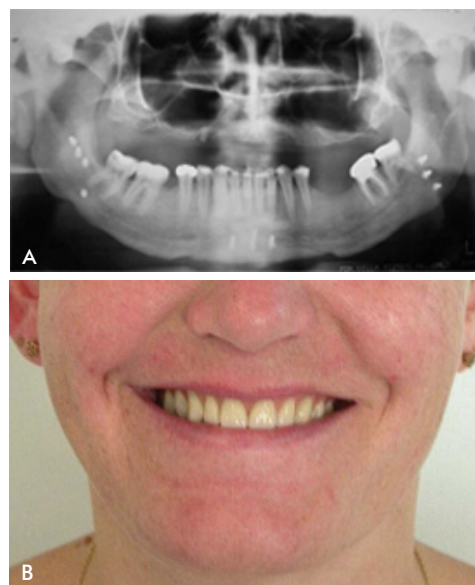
A. Postoperative panoramic radiography. B. Late postoperative frontal view.
